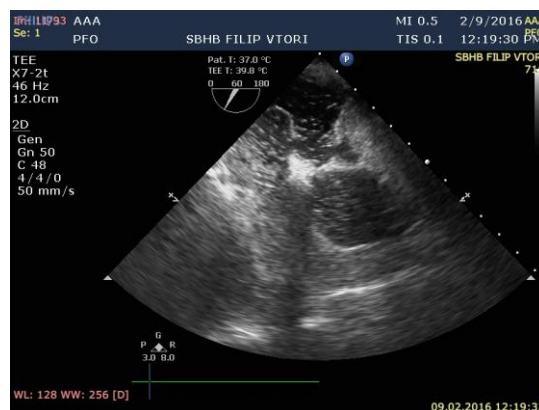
Transesophageal echocardiography (TEE) in a patient with PFO
